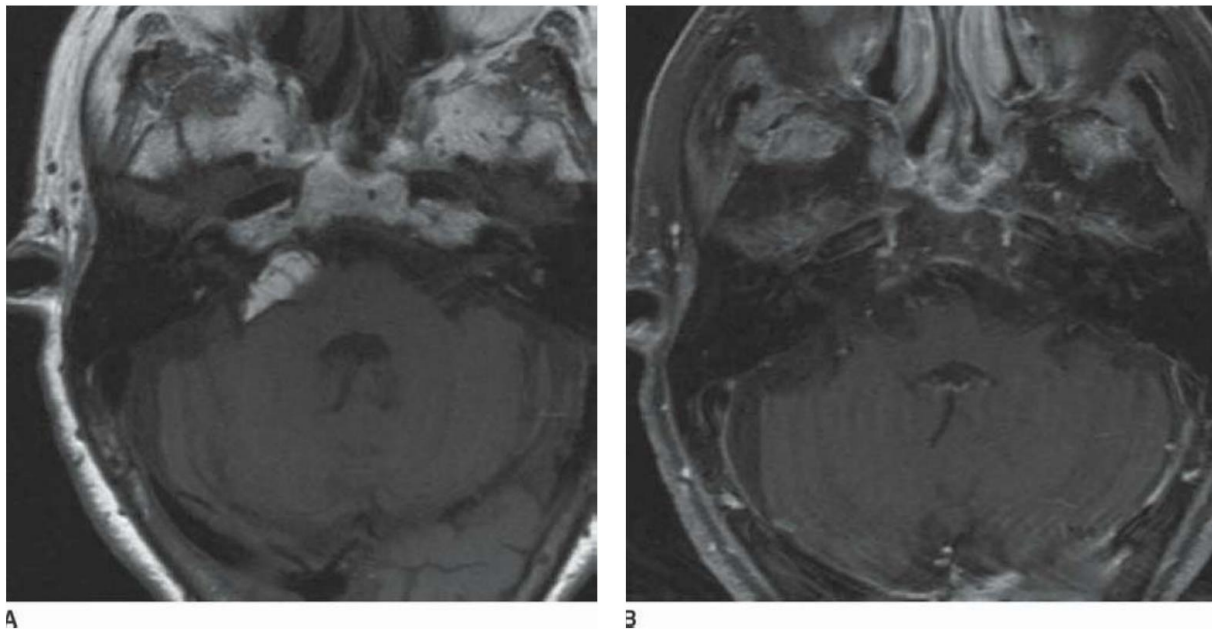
Axial T1-weighted unenhanced MRI image at the level of the IAC demonstrating a right CPA lipoma (A). The diagnosis is confirmed with a postcontrast fat-suppressed T1 MRI image as this lesion appears dark (B).
